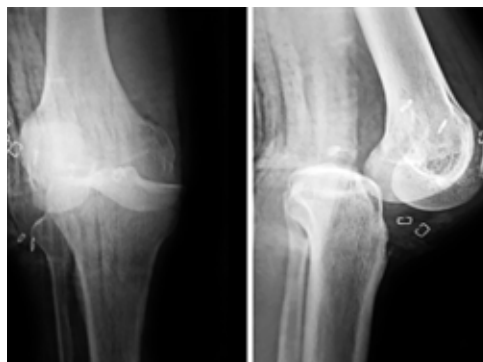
X-ray knee AP and lateral views showing posterior knee dislocation.
